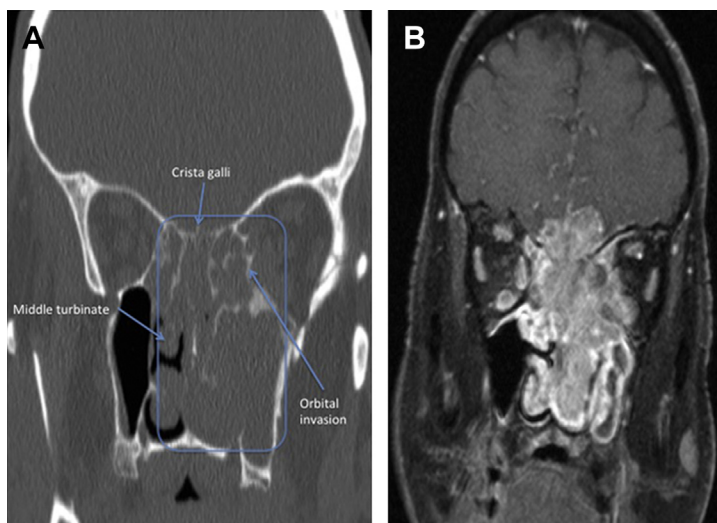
Coronal CT (A) and T1-weighted MRI (B) show highly infiltrative sinonasal carcinoma centered within the left nasal cavity with extensions to the orbit, anterior cranial fossa, soft tissue of the nose, and pterygoid fossa.
